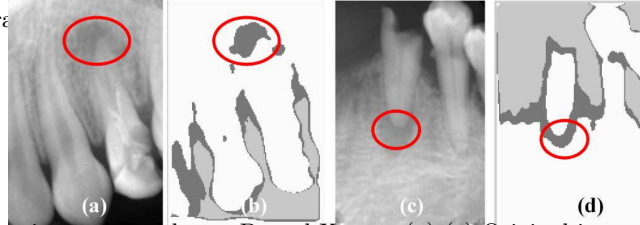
Experimental Results on Dental X-rays. (a) (c) Original image with problem area circled by dentist. (b) (d) Segmented image.
